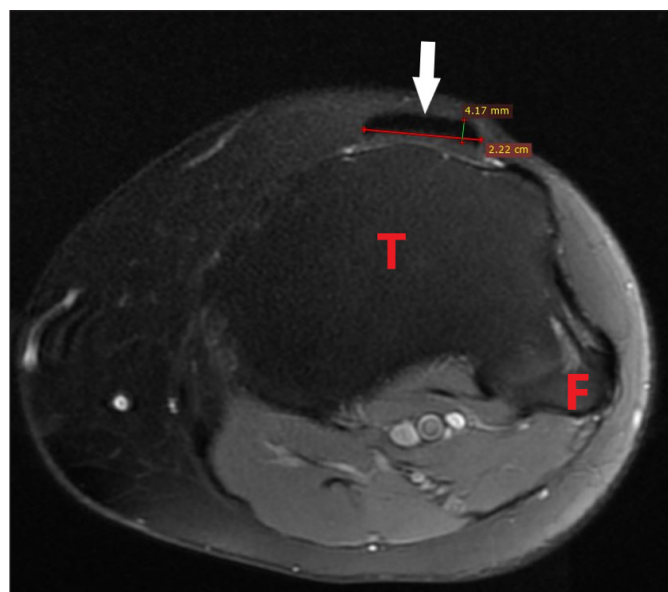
Thickness and diameter measurements of the patellar tendon on transverse MR image (fat-suppressed PD T2A). T: Tibia, F: Fibula, White arrow: patellar tendon (section taken 1 cm from the distal attachment level).
